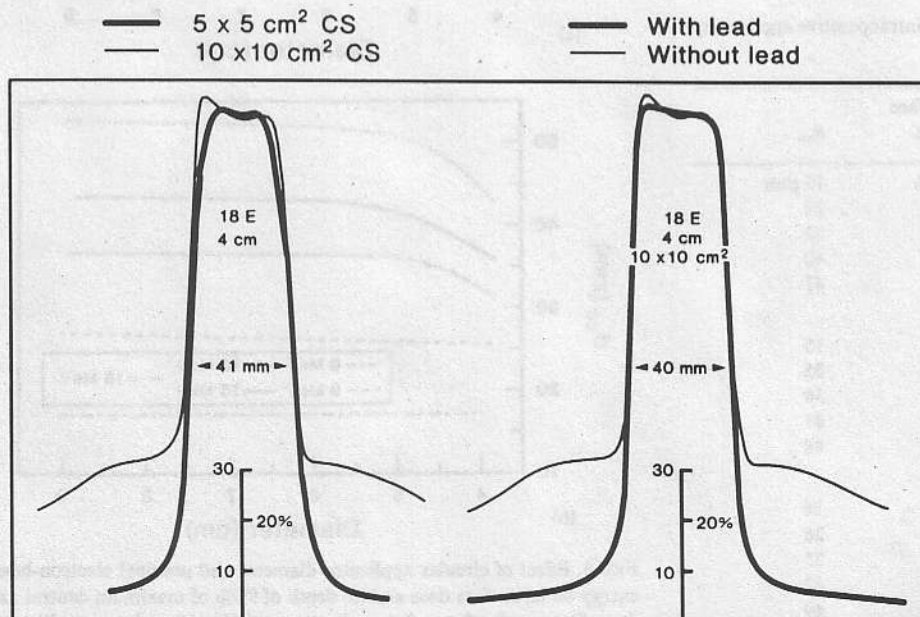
Cross-field behavior at 20 mm depth for two settings of x-ray collimator jaws (left), and the same x-ray collimator jaw setting with and without 3 mm of lead added at top of spacing anulus (right).
